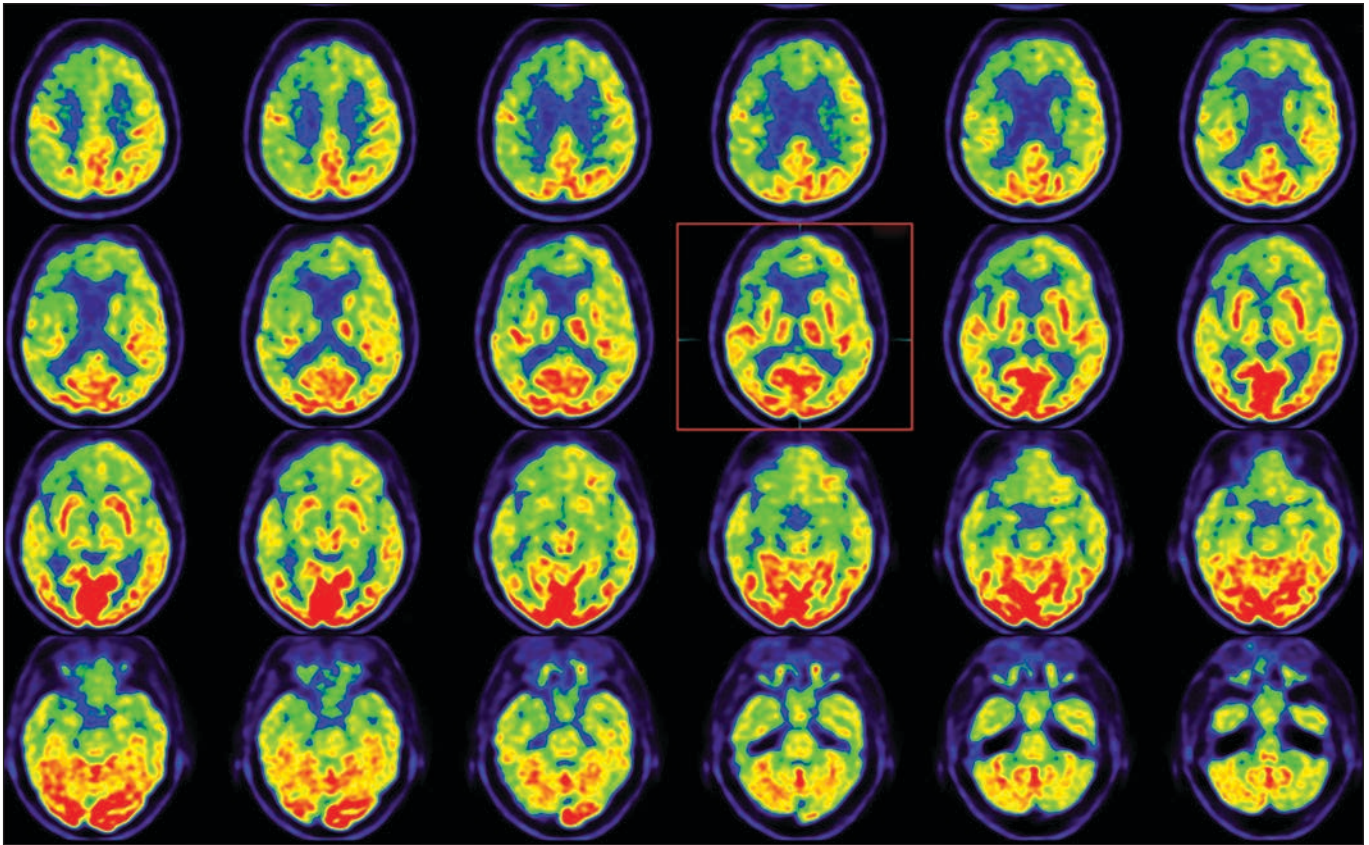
73-year-old woman with behavioral variant frontotemporal dementia. Axial fusion PET and FLAIR MR images show abnormal FDG distribution and decreased radiotracer uptake primarily in right frontal lobe and striking hypometabolism in contralateral left cerebellar hemisphere. Findings are consistent with crossed cerebellar diaschisis. Red box indicates dominant clinical image with findings suggestive of behavioral variant frontotemporal dementia. There is marked asymmetrical hypometabolism within frontal and temporal lobes.
